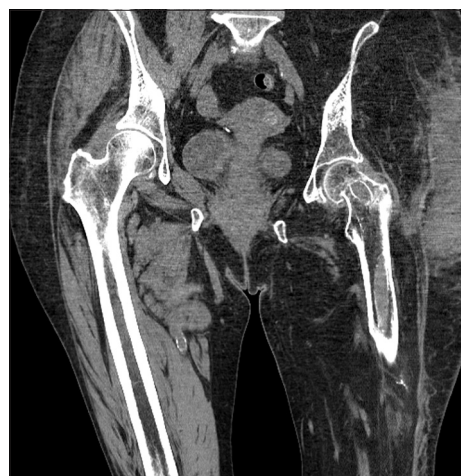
CT scan documenting sub-capital fracture of the femur
